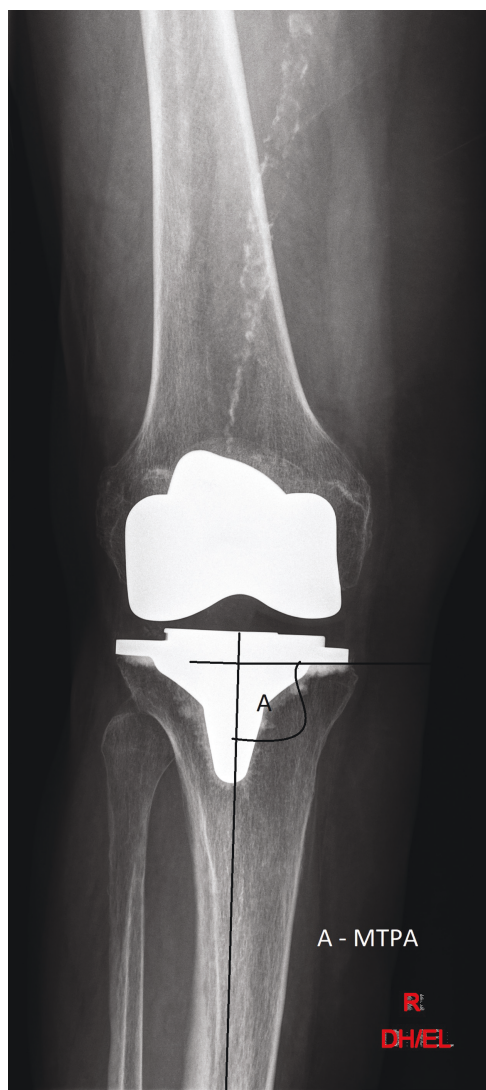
X-ray of the measurements of the MPTA. MPTA, medial proximal tibial angle.
